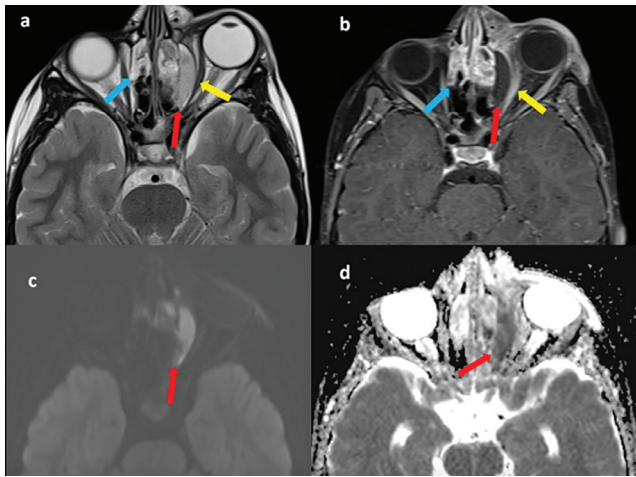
Thirteen-year-old female with ethmoidal sinusitis complicated by orbital subperiosteal abscess. Contrast-enhanced brain MRI (a, b) and diffusion-weighted imaging (c, d) show ethmoidal sinusitis with erosion of the lamina papyracea (blue arrow) and a rim-enhancing, loculated retro-orbital subperiosteal collection exhibiting diffusion restriction (red arrow), consistent with an abscess. The medial rectus muscle appears thickened and displaced laterally (yellow arrow), indicating inflammatory involvement and mass effect from the adjacent abscess. These findings highlight the typical pathway of infection spread from the ethmoid sinus through the lamina papyracea into the orbital compartment
